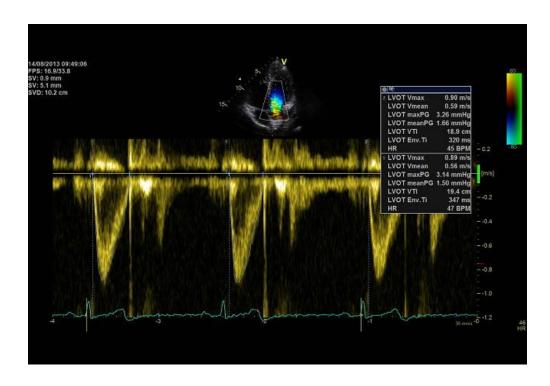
Pulsed-wave spectral Doppler recording showing measurement of the left ventricular outflow velocity time integral.
